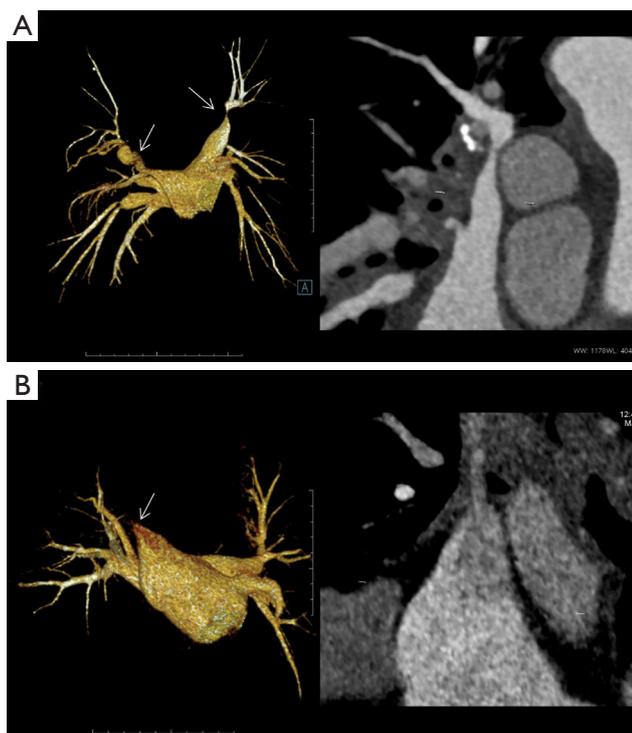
Representative CT venography of fibrosing mediastinitis. (A) Pulmonary vein stenosis induced by fibrosing mediastinitis; (B) pulmonary vein occlusion caused by fibrosing mediastinitis. CT, computed tomography.
